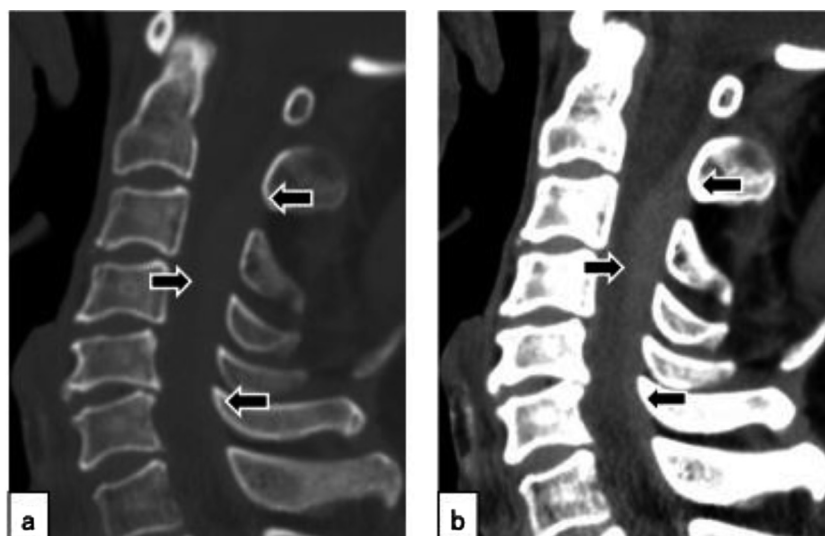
Comparison of computed tomography (CT) scans based on window settings (sagittal views). Epidural hematomas are easier to identify on CT scans with soft tissue window settings (b) rather than CT scans with bone window settings (a) (arrows).
